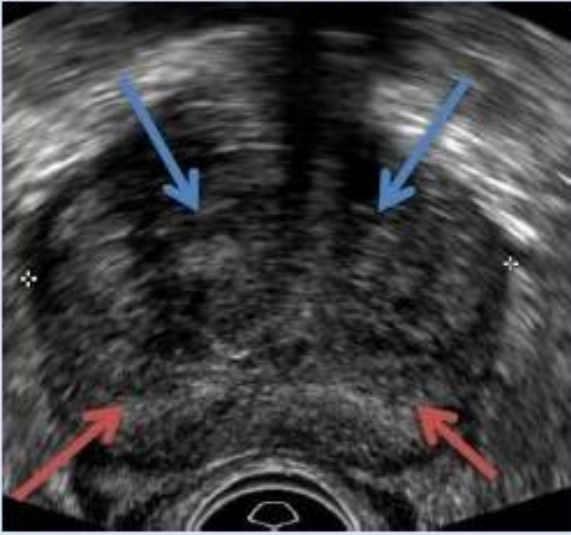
Gray-scale Transrectal Ultrasound (TRUS) of prostate. Axial (left) and sagittal (right) views are used to calculate prostate volume. We also look for any hypoechoic lesions in CZ and PZ. PZ has been marked by red arrows. Blue arrows have been used to localize TZ. Orange arrow localizes the CZ.
